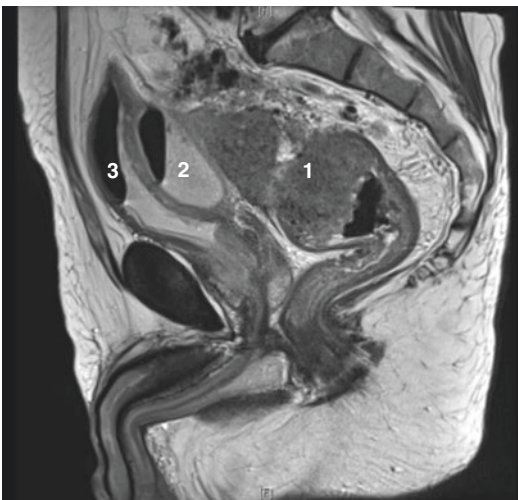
MRI demonstrating locally advanced rectal cancer (1) with anterior perforation and associated abscess cavity (2) adjacent to bladder (3). The patient required total pelvic exenteration
